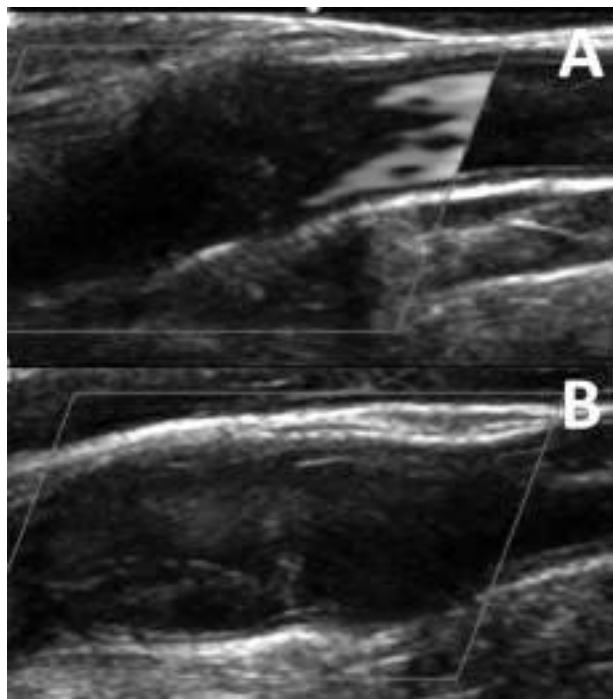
2B. B-mode carotid PW Doppler (longitudinal) showing occlusion in the distal right common carotid artery (2A); bifurcation and internal carotid artery with a hypoechoic mobile structure (2B)
